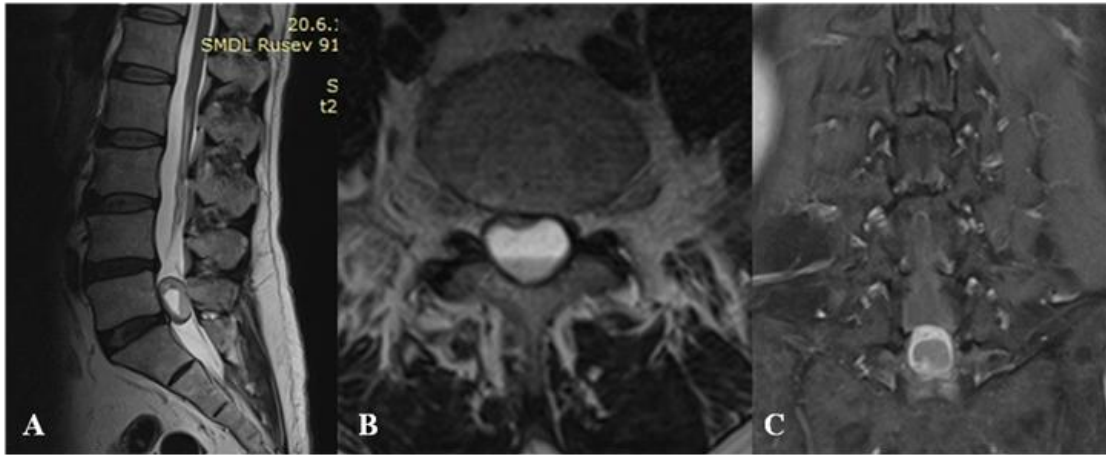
MRI image of filum terminale myxopapillary ependymoma:
